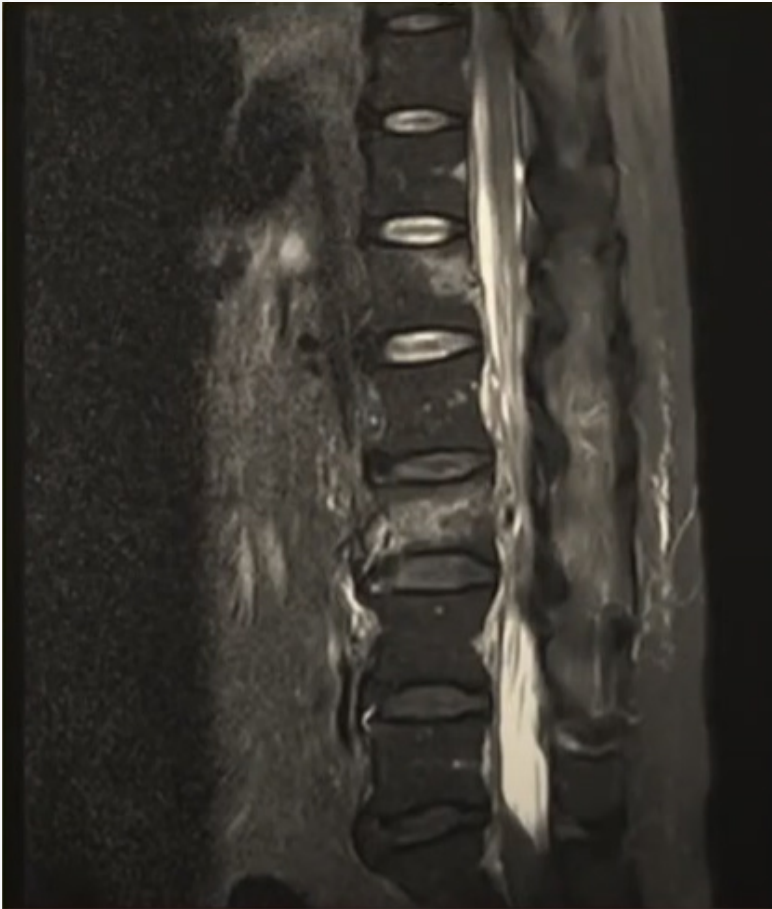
Lumbar spinal magnetic resonance imaging (MRI) in 2021.
